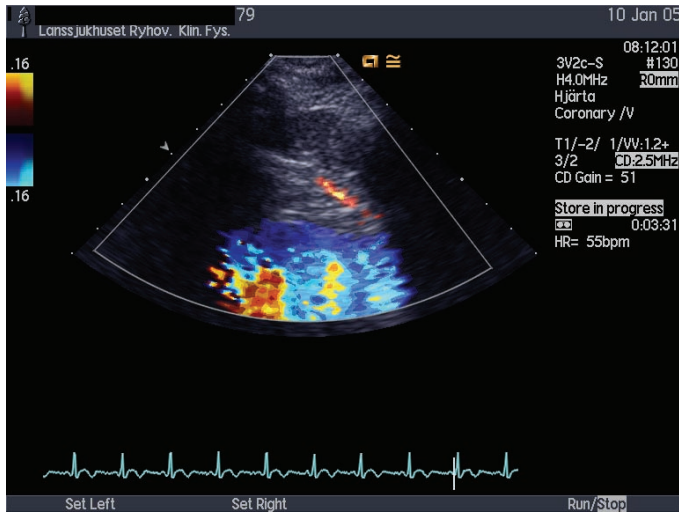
Color Doppler recording of LAD flow.
